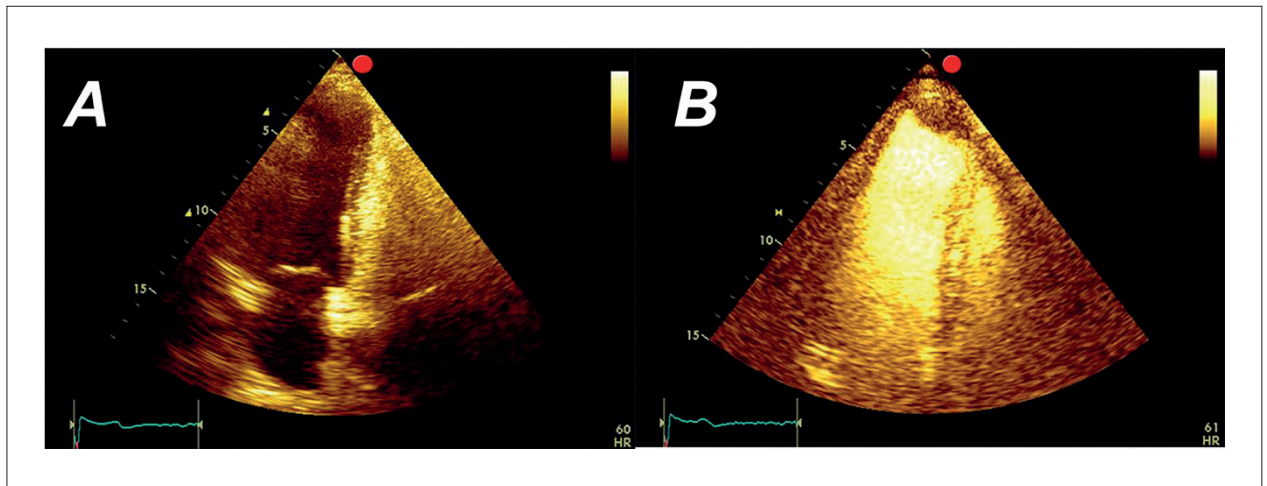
Apical three-chamber view. In (A), the lateral wall and apex are not visualized. In (B), contrast enhancement allows proper delineation of previously nonvisualized segments and reveals the presence of an apical thrombus.
